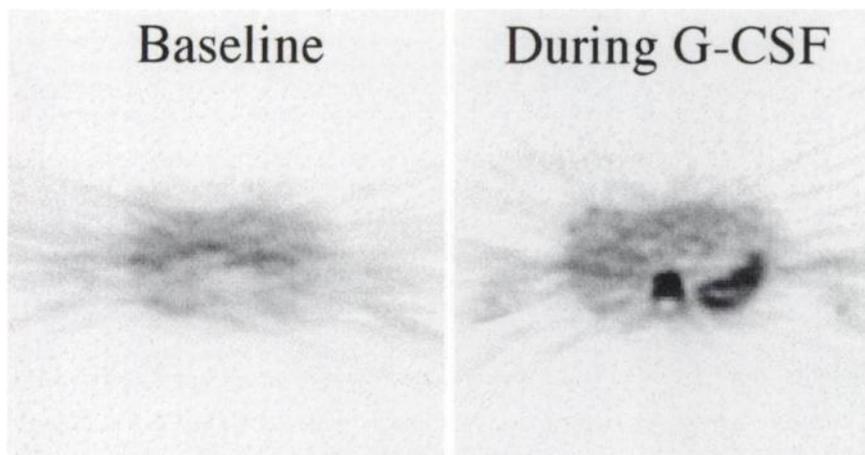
Transverse FDG PET images in patient 11. During granulocyte colony-stimulating factor (G-CSF) treatment, substantially increased FDG uptake is observed in bone marrow and in spleen.
